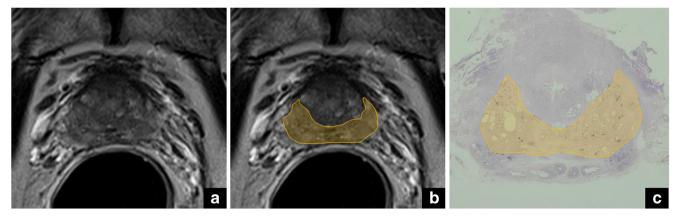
Axial T2-weighted image (a) of the posterior base. The yellow areas (b) correspond to the protrusion of a large adenoma in the peripheral
